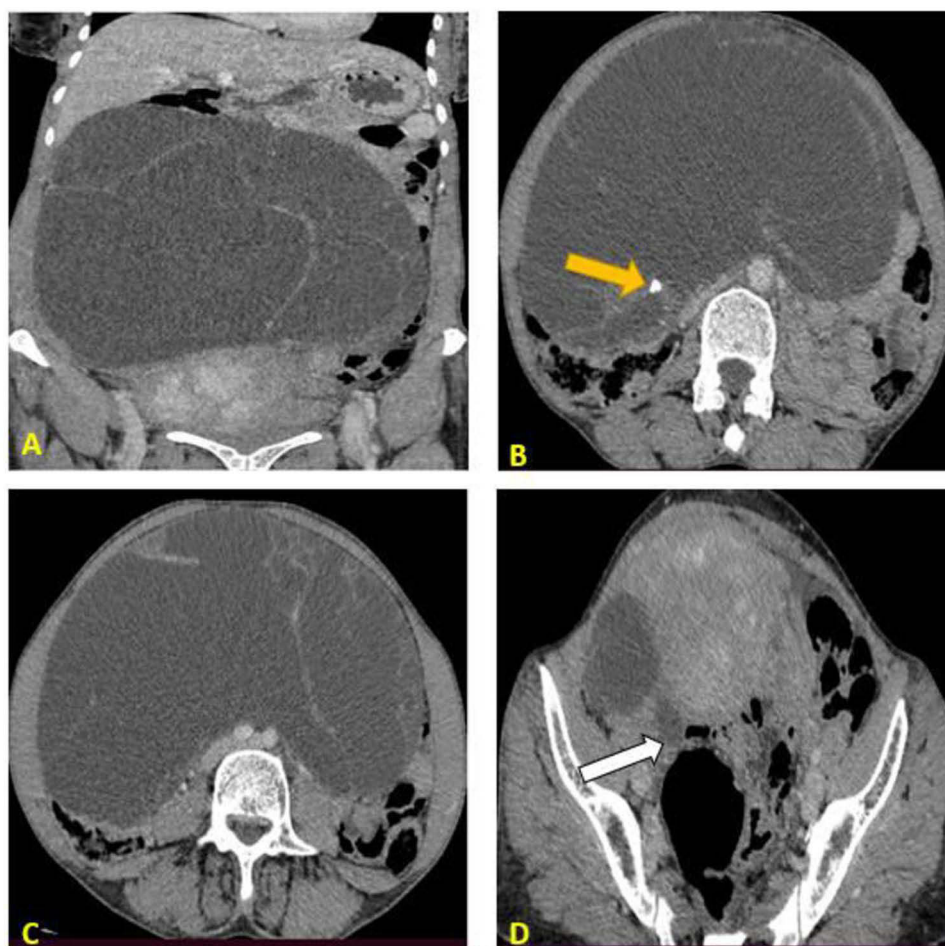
(A–D) Post contrast abdominopelvic CT scan revealing 22.6×20.9×13.9cm multiseptated pelvic mass extending until the level of the pancreas (A–C). Calcification is seen within the mass (B) Yellow arrow). No solid component is present. Left ovary could not be defined separately from the mass. Small cystic lesion in the right adnexal area, representing right ovary (D) White arrow).
